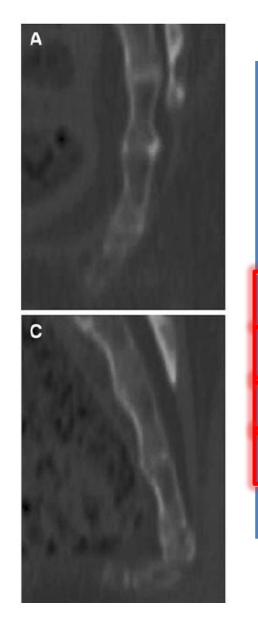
Types of coccyx according to Postacchini and Massobrio (1983) classification in multislice computed tomography (MSCT). a Type I, b type II, c type III, d type IV
